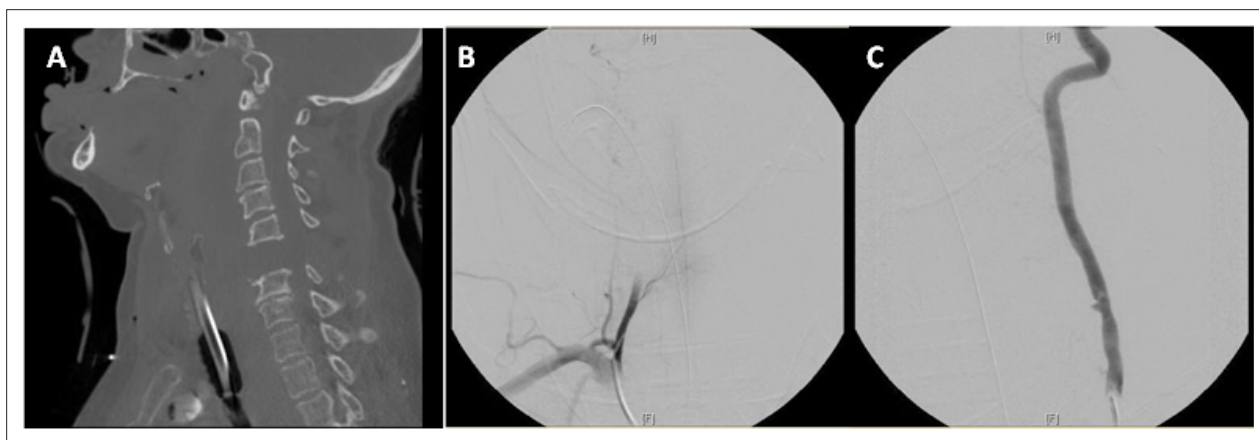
(A) Sagittal computed tomography scan demonstrating a vertical distraction injury of the C5-6 cervical spine. (B) Right vertebral angiogram demonstrating complete transection and (C) left vertebral angiogram demonstrating proximal focal dissection.
